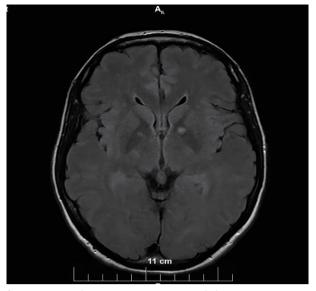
T1 brain MRI: Symmetrical hyperintense toxic changes in globus pallidum (reprinted with patient's permission)
